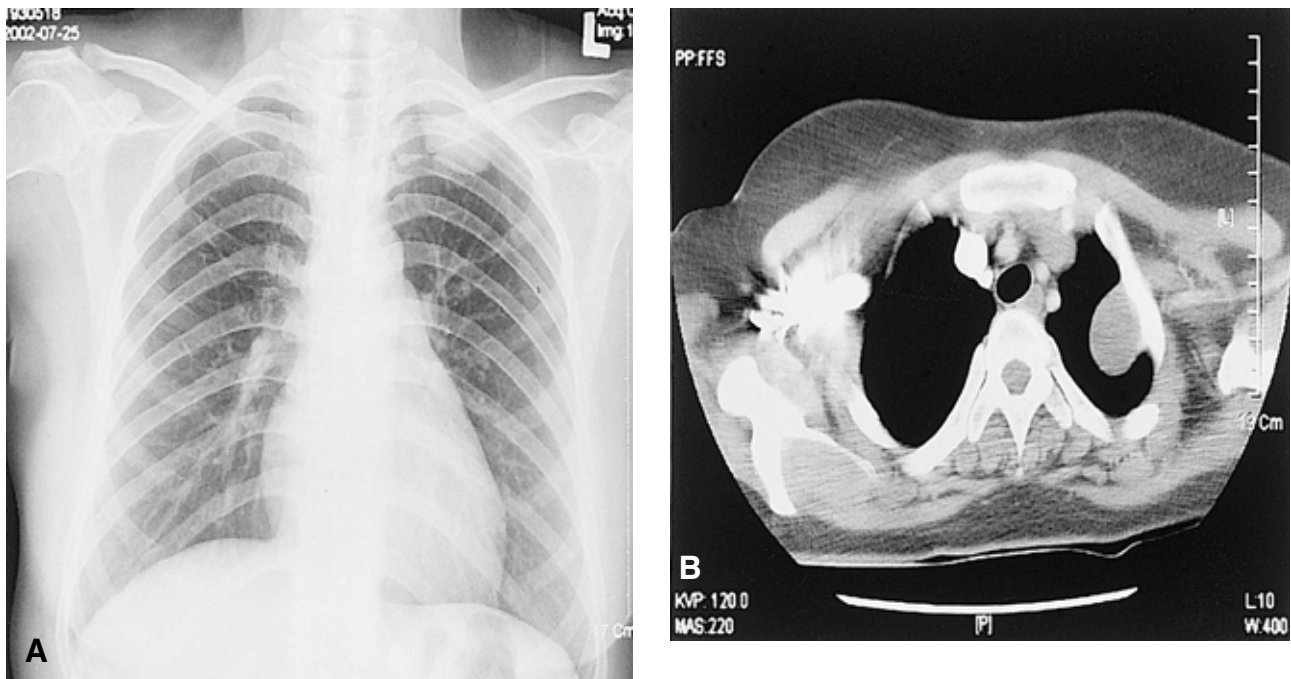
Chest PA (A) and CT scan (B) of case II show a homogenous mass measuring 3.5 cm×2.5 cm at the left upper lung field with a well-demarcated margin.
